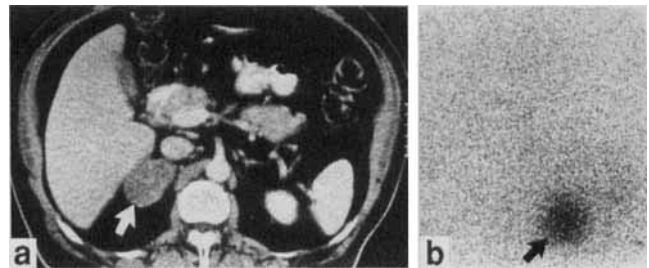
a Abdominal computed tomography scan identified a large (6 cm) right adrenal mass (arrow). b Posterior chest and upper abdominal ¹³¹I-6-β-iodomethyl-19-norcholesterol scintiscan depicts a solitary focus of radiotracer uptake that corresponds to a Cushing's adenoma. The contralateral adrenal is not visualized due to suppression of adrenocorticotropic hormone and ¹³¹I-6-β-iodomethyl-19-norcholesterol uptake into the normal adrenal
